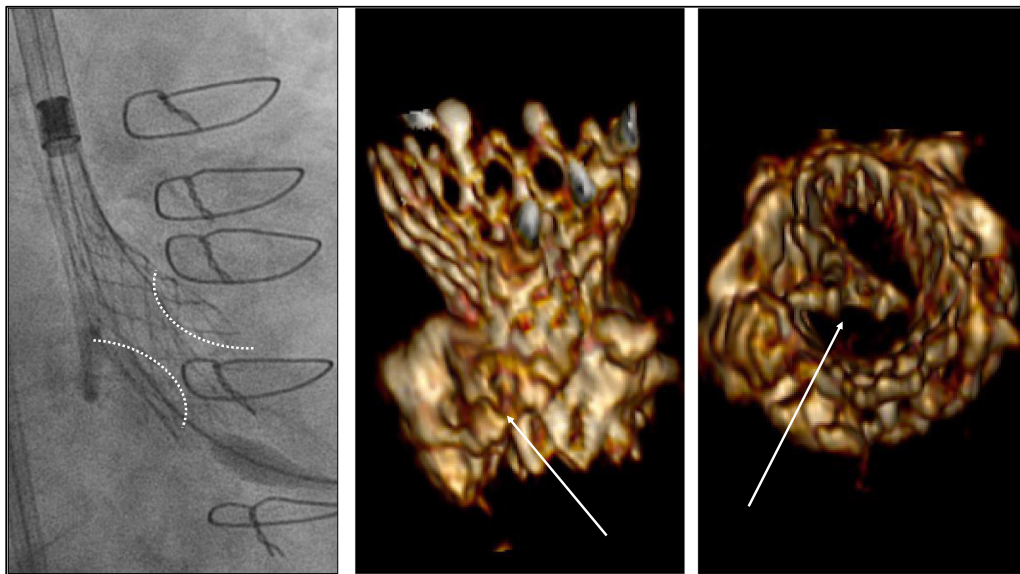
Typical examples of infolding. Left: Double wrinkling along the stent frame resulting in an all-over invagination of the inflow and outflow tract and a reduced diameter of the unsheathed part of the transcatheter heart valve. Middle and right: Postprocedural multislice computed tomography 3D-reconstruction with diagnosis of infolding.
